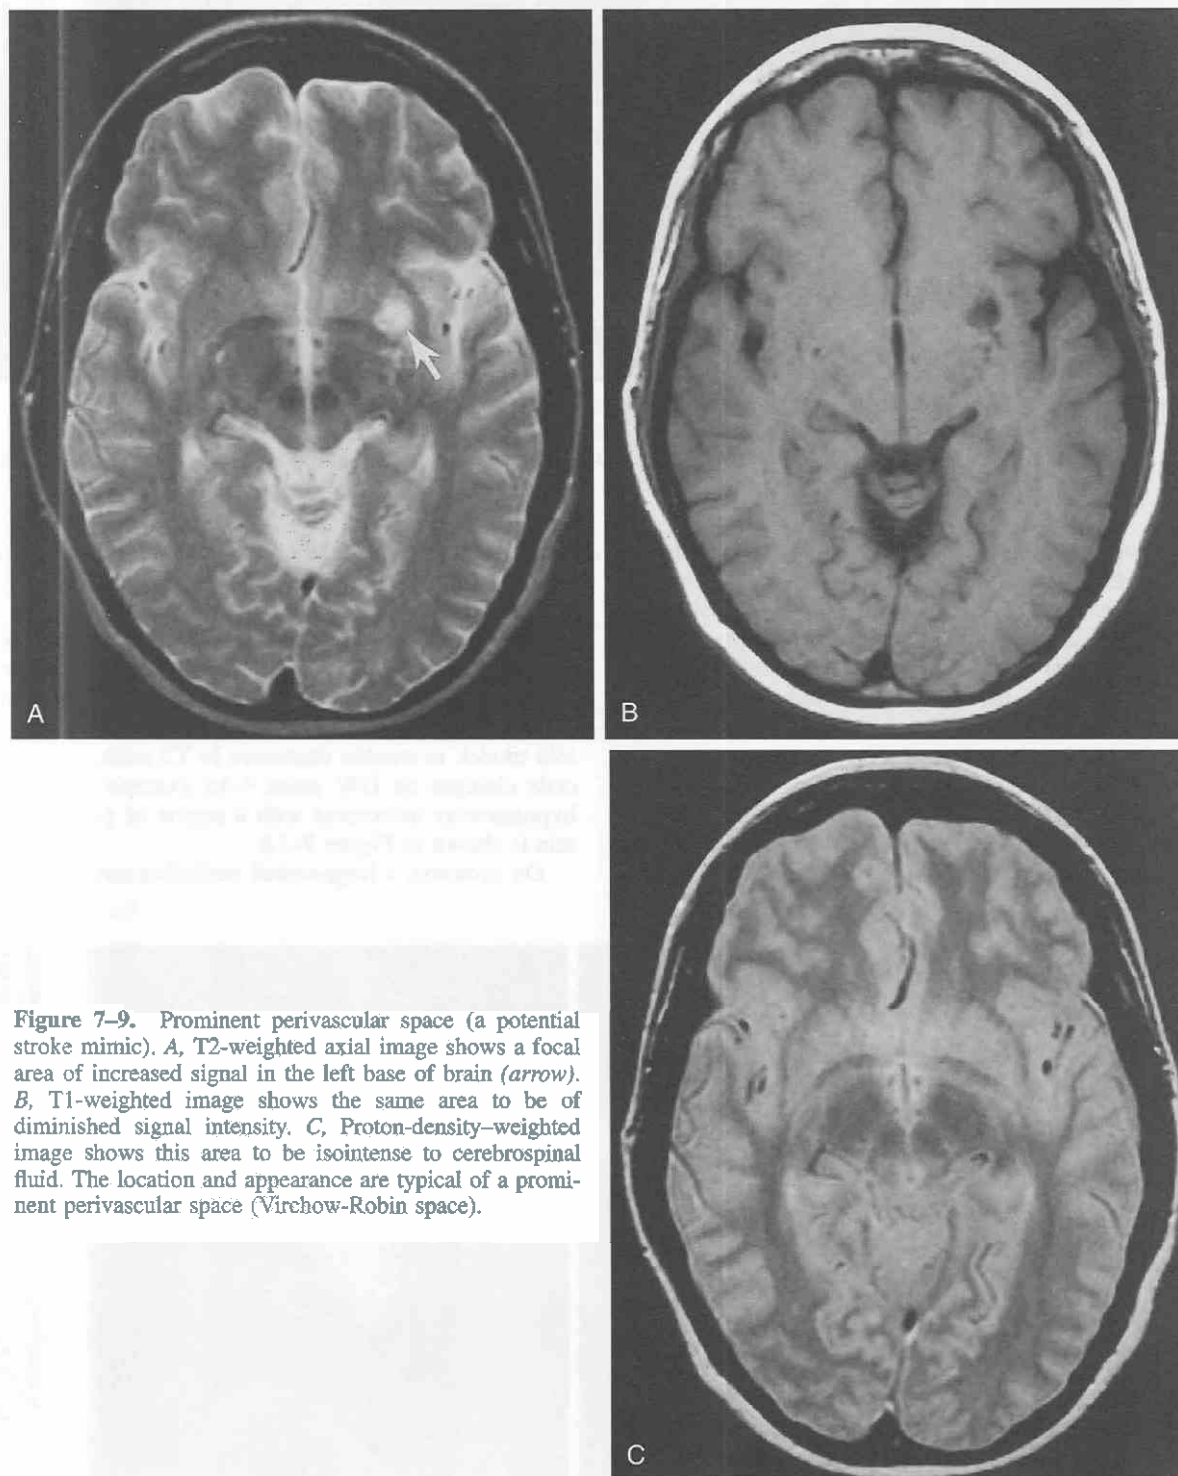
Prominent perivascular space (a potential stroke mimic). *A*, T2-weighted axial image shows a focal area of increased signal in the left base of brain (*arrow*). *B*, T1-weighted image shows the same area to be of diminished signal intensity. *C*, Proton-density-weighted image shows this area to be isointense to cerebrospinal fluid. The location and appearance are typical of a prominent perivascular space (Virchow-Robin space).
